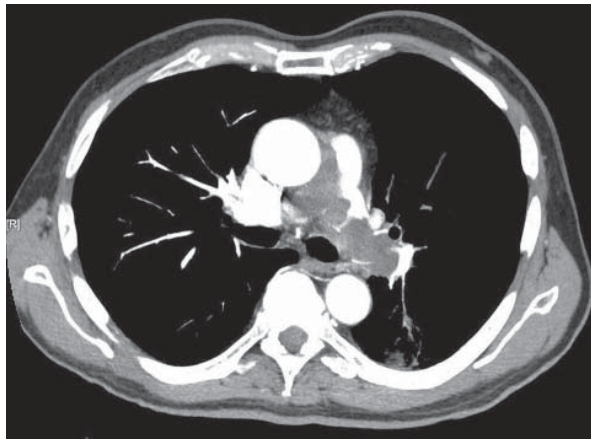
Contrast-enhanced computed tomogram of the chest shows pulmonary nodules and a large, enhanced lesion in the left pulmonary artery.
